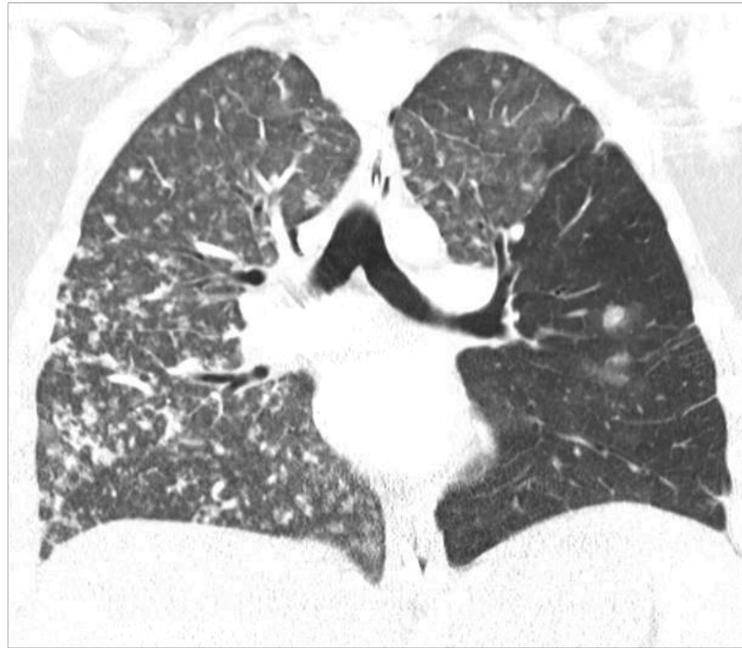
Coronal view of a CT Chest Angiogram with IV contrast demonstrating diffuse ground glass infiltrates sparing the portion of left lung that is infarcted. This is consistent with pulmonary talcosis via the intravenous route.
